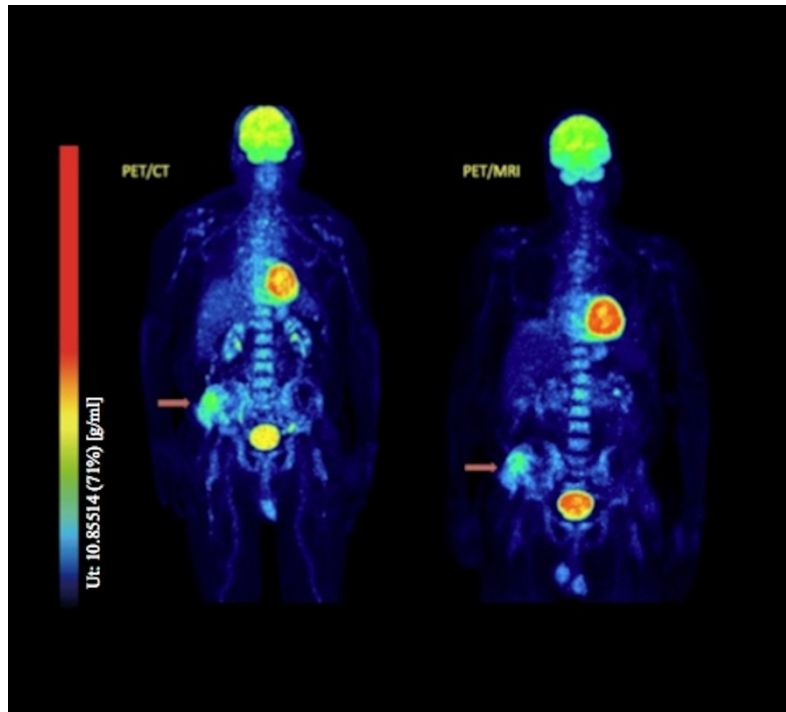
Multiple intensity projection (MIP) images of a 78-year old patient with newly diagnosed stage III MM, derived from PET/CT 60 min p.i. (left) and PET/MRI 120 min p.i. (right). The patient demonstrates intense diffuse ^{18}F -FDG bone marrow uptake along the spinal column demonstrated with both PET/CT and PET/MRI. Moreover, a big focal lesion in the right os ilium that infiltrates the soft tissues is depicted with both techniques (arrow). Mixed pattern of ^{18}F -FDG uptake. The values of the scale bar refer to g/ml. (Lt: lower threshold; Ut: upper threshold).
